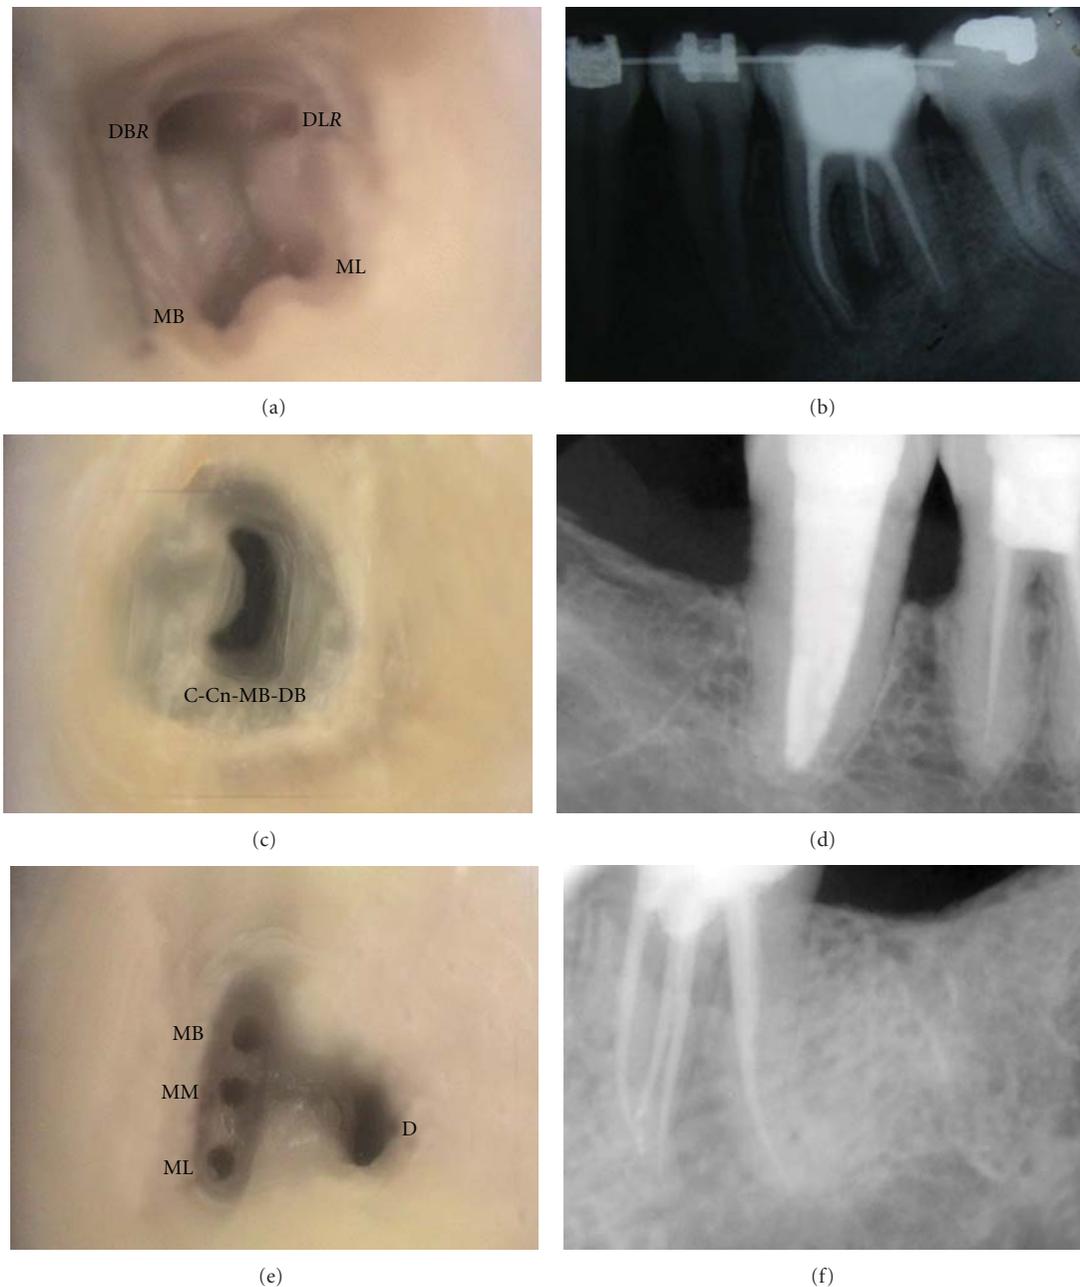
Clinical and radiographic images of anatomic aberrations demonstrating the use of the proposed nomenclature. (a, b) Pulp chamber floor showing an additional distolingual root and canal (DLR) and the distobuccal canal (DBR) in the distobuccal root; MB—mesiobuccal, ML—mesiolingual. (c) C-shaped centrally located (Cn) canal extending from the mesiobuccal (MB) to the distobuccal (DB) portion of the tooth; within a single root (d). (e, f) Three canals in the mesial root of a mandibular first molar; MM—middle mesial, D—distal.
